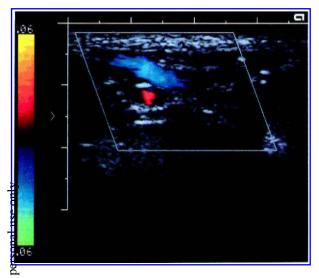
Longitudinal image of lower spermatic cord superior to left testis. Hypoechoic linear structure (arrow) represents dilated vein. (Reprinted with permission from Meacham RB, Townsend RR, Rademacher D, Drose JA: The incidence of varicoceles in the general population when evaluated by physical examination, gray scale sonography and color Doppler sonography. J Urol 1994;151:1535-1538.)
